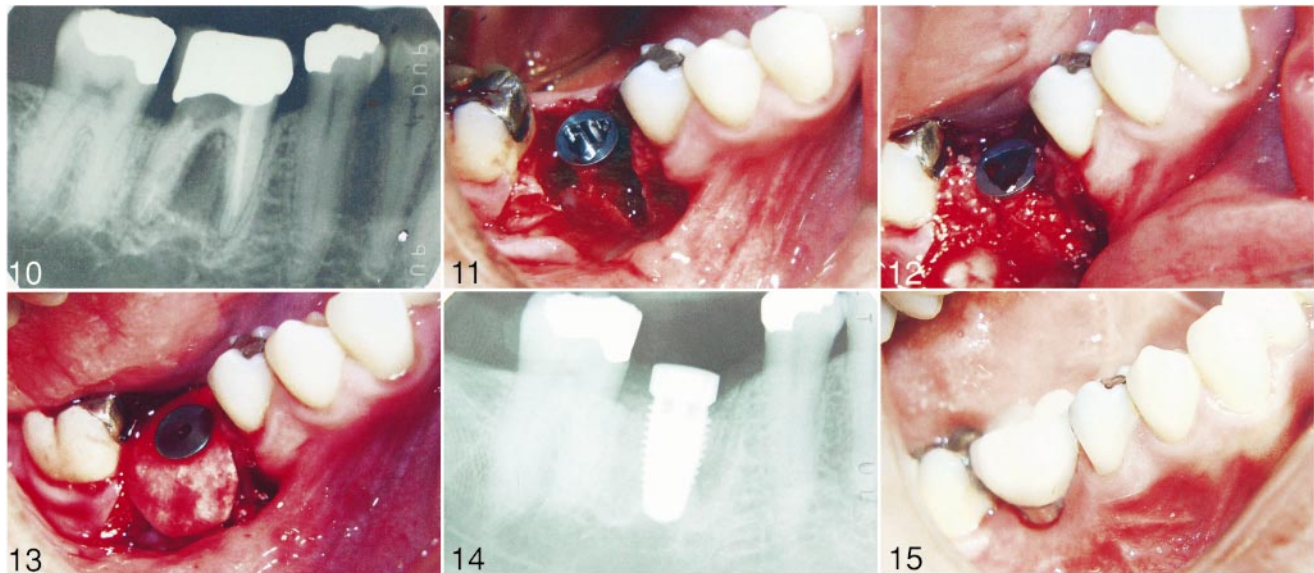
Radiographic view of case 2 preoperatively. FIGURE 11. Clinical view of the implant into the extraction socket. FIGURE 12. Clinical view of the implant with the bone augmentation material. FIGURE 13. Clinical view of the collagen membrane covering the graft material. FIGURE 14. Radiographic view of the implant 3 months after the procedure. FIGURE 15. Clinical view of the restored implant.
